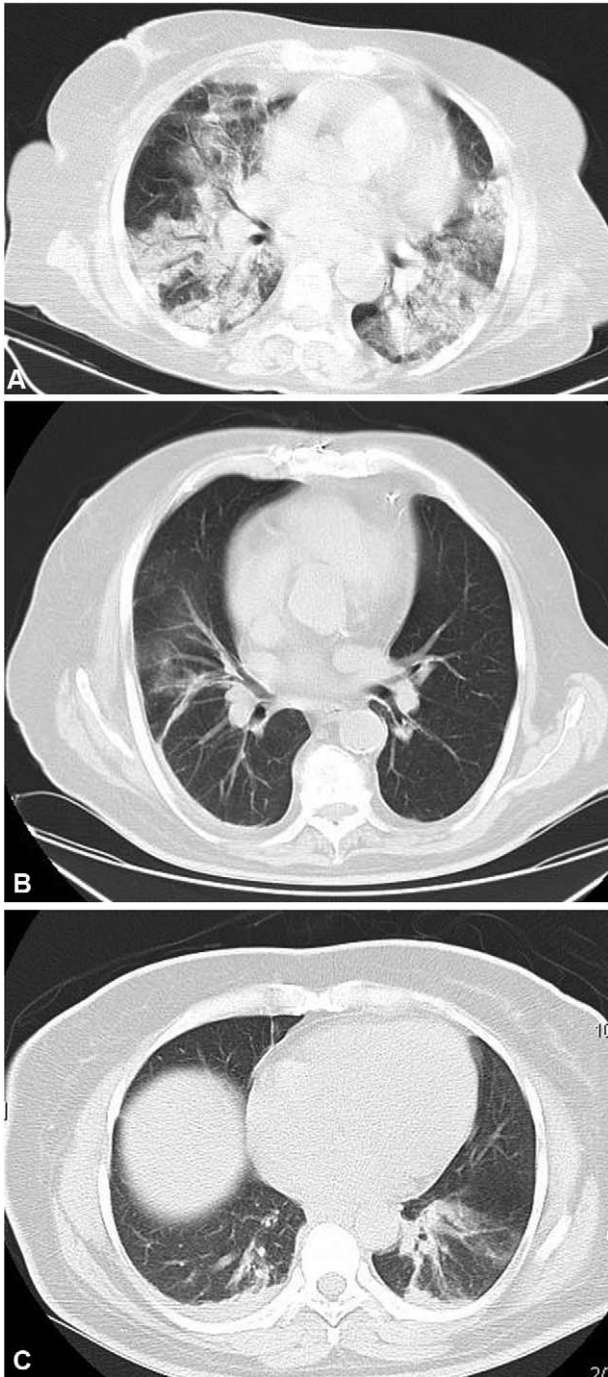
Chest CT scan of COVID-19 pneumonia. A, Case 1: Bilateral large areas of ground-glass opacities and consolidations, giving a white lung appearance, 19 d after an elective incisional hernia repair. B, Case 2: Unilateral peripheral ground-glass opacities 16 d after laparoscopic cholecystectomy. C, Case 3: Bilateral dependent consolidations in lung bases with minimal pleural effusion 3 d after hysterectomy and cholecystectomy.
